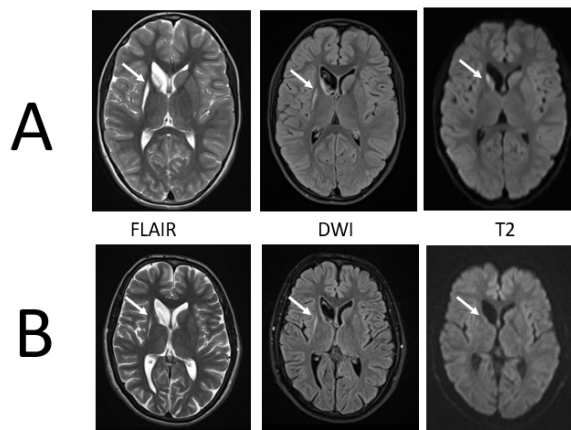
(A) Brain MRI of patient showing abnormal T2/FLAIR signal in right caudate and putamen, restricted diffusion in right caudate. (B) Brain MRI of patient's brother showing marked atrophy of right caudate, putamen and globus pallidus, and with no associated diffusion restriction.
